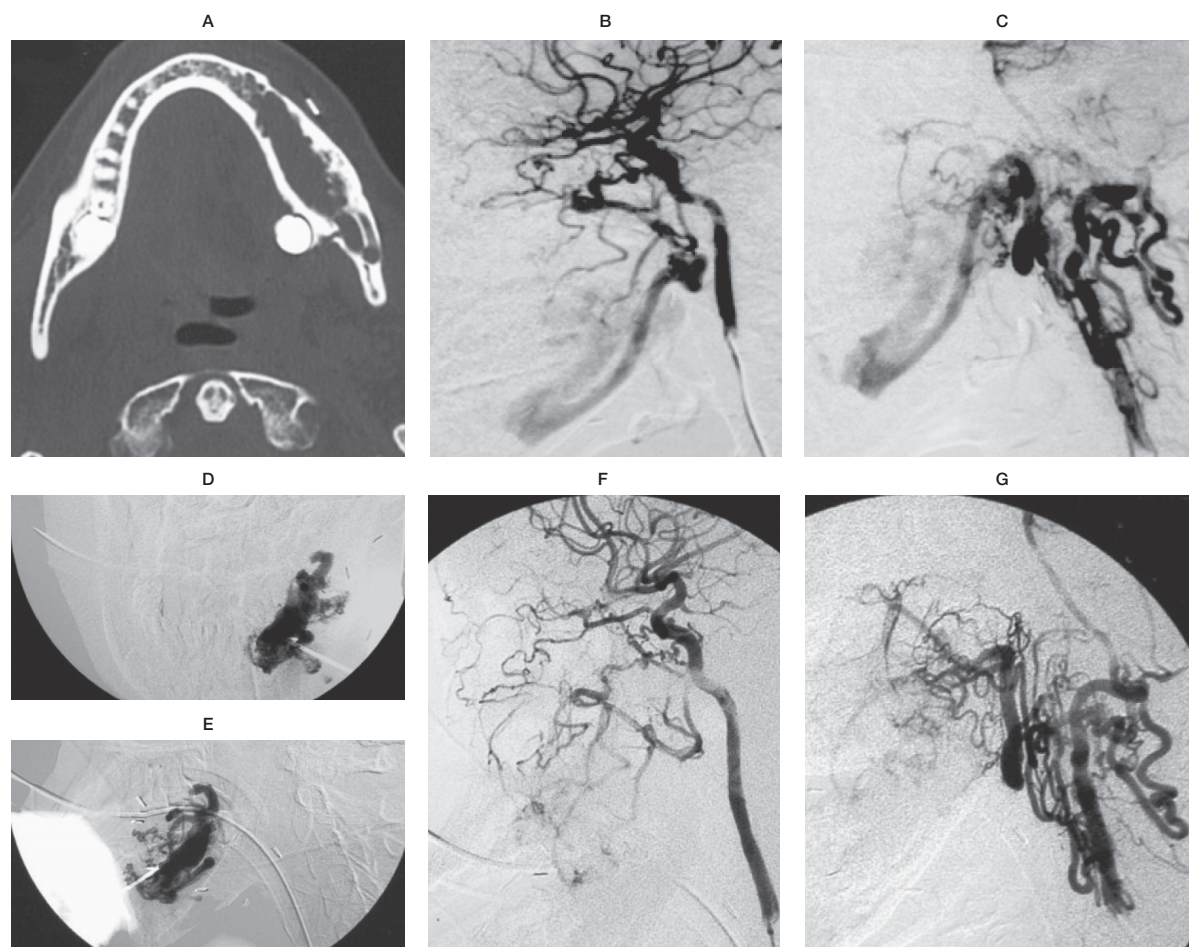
Intraosseous AVM of mandible in a 16-year-old female who presented with massive bleeding per gum status post external carotid artery ligation. A) Axial CT scan revealing osteolytic appearance of the malformation. B) Left internal carotid angiogram exhibiting reconstitution of the internal maxillary artery from anastomosis of ILT with consequence supply to the AVM via inferior alveolar artery. C) Recruitment of the external carotid system from anastomosis of vertebral artery too. D) Frontal and E) Lateral projection during NBCA embolization via direct transosseous puncture. F) Left internal carotid angiography and G) Left vertebral angiography immediate post embolization demonstrating complete obliteration of the malformation.
